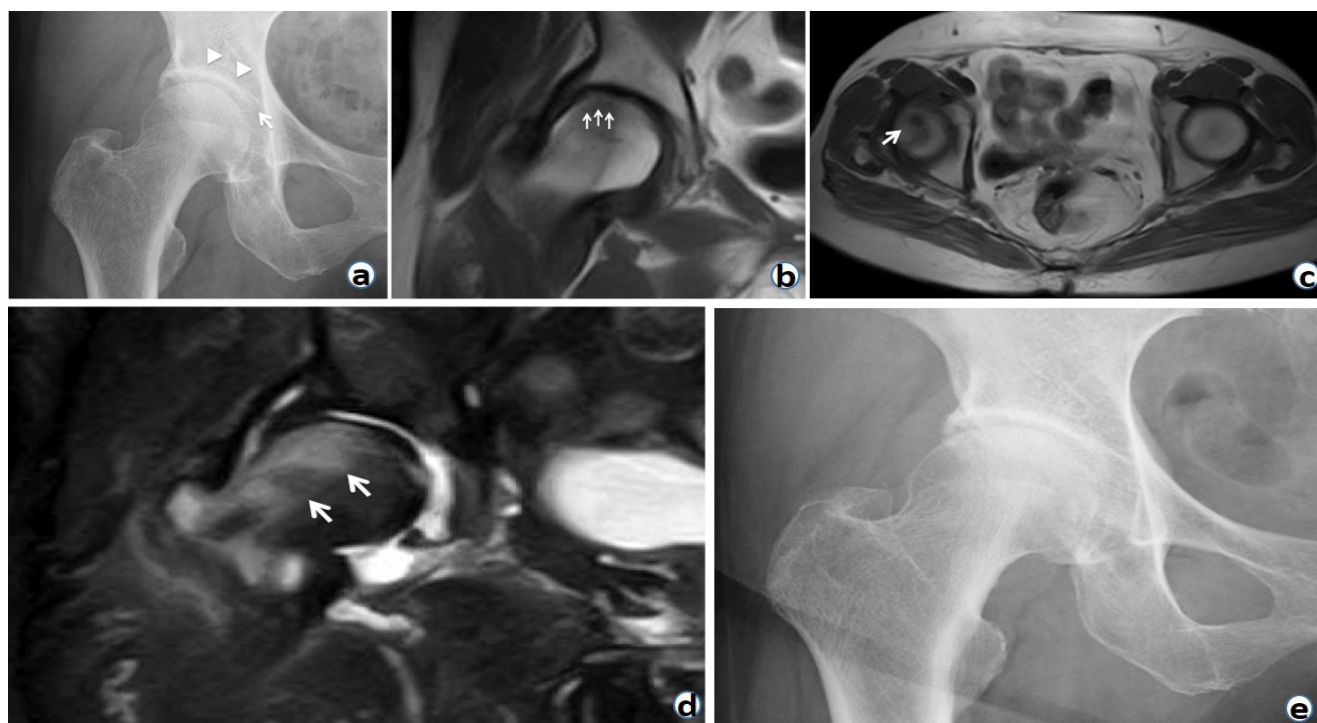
X-rays and magnetic resonance imaging (MRI) images of the first subchondral insufficiency fracture (SIF) (a) X-ray at first onset of SIF shows no crescent sign at the femoral head. An osteophyte on the acetabular fossa (white arrow) and subchondral sclerosis of the acetabulum (white arrowheads) are observed. Center-edge angle is 17°, sharp angle is 43°, and acetabular head index is 70%. (b) Coronal section of a T1-weighted image on MRI at the first SIF shows a low-intensity band parallel to the articular cartilage surface at a lateral site on the femoral head (white arrows). (c) Axial section of a T1-weighted image on MRI shows a low-intensity area at the anterior side of the femoral head (white arrow). (d) Coronal section of a T2-weighted image on MRI shows diffuse high signal intensity around the low-density band (white arrows). (e) X-ray shows no collapse of the femoral head at 3 months after onset of the first SIF.
